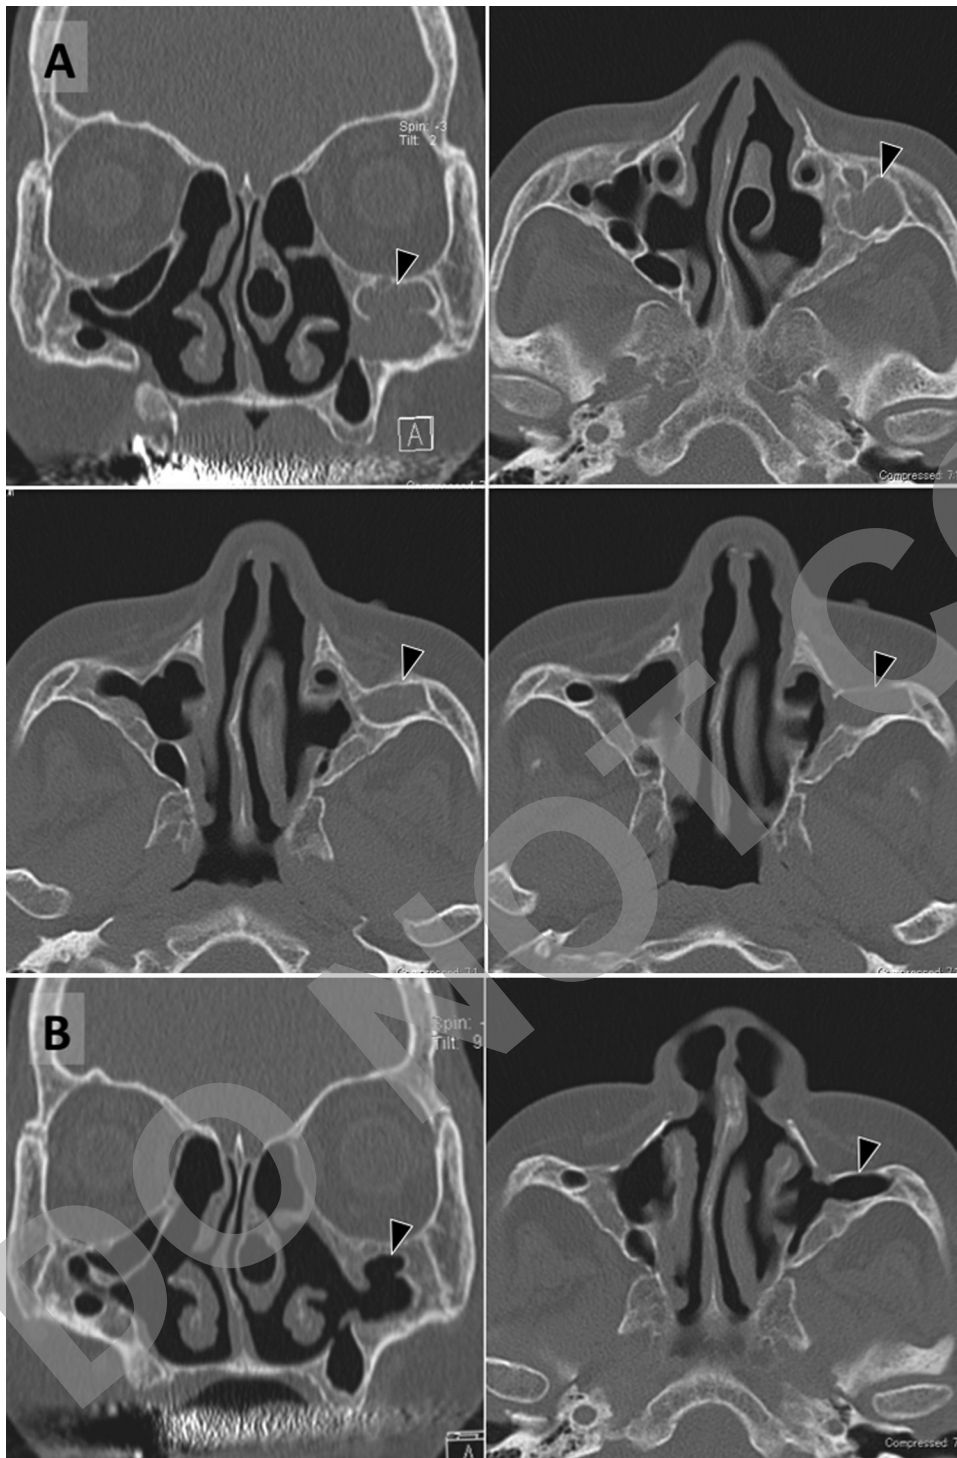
(A) Mucocoele of the maxillary sinus after Caldwell-Luc operation is shown on the left side (arrowhead). (B) Postoperative computed tomography reveals patency and preservation of the inferior turbinate 6 months after surgery (arrowhead).
